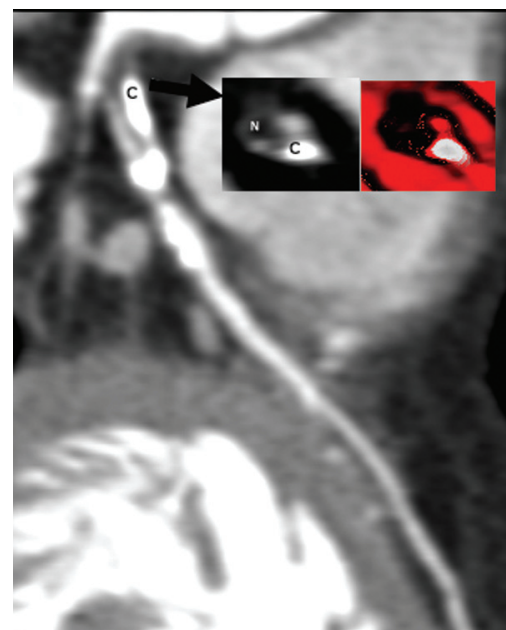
Severe calcifying plaque (C, white) proximally with a noncalcifying plaque component (N, black) shown with multislice computed tomography coronary angiography. Note that the distal left anterior descending artery (LAD) is spared from calcifying plaque and qualifies for suturing the anastomosis. The inlay images (black arrow) show a cross-sectional slice through the LAD proximally at the level of the black arrow.
